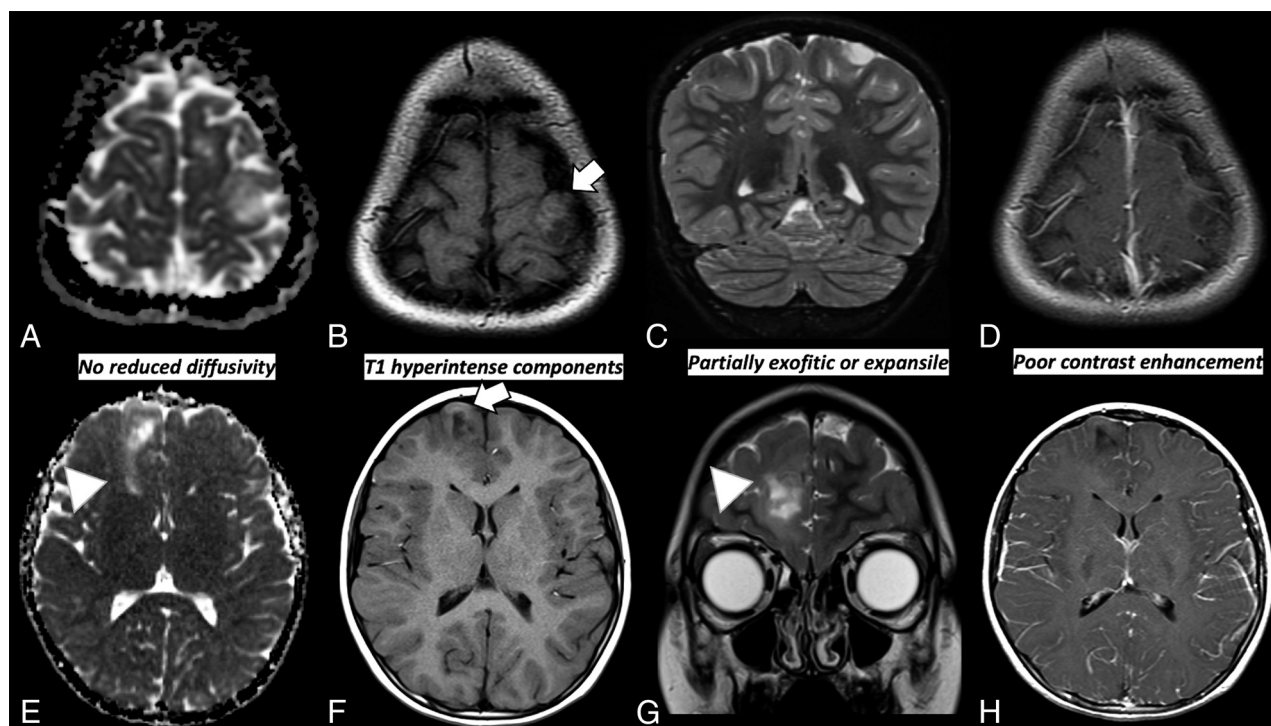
AG, MYB-QKI fusion positive in 2 different patients. Axial ADC map and T1-weighted as well as coronal T2-weighted, and axial T1-weighted postcontrast images of the brain in 2 different patients show a cortical-based lesion with internal T1-hyperintense components (similar to the adjacent white matter) (white arrow) and a stalklike sign (arrowhead).
